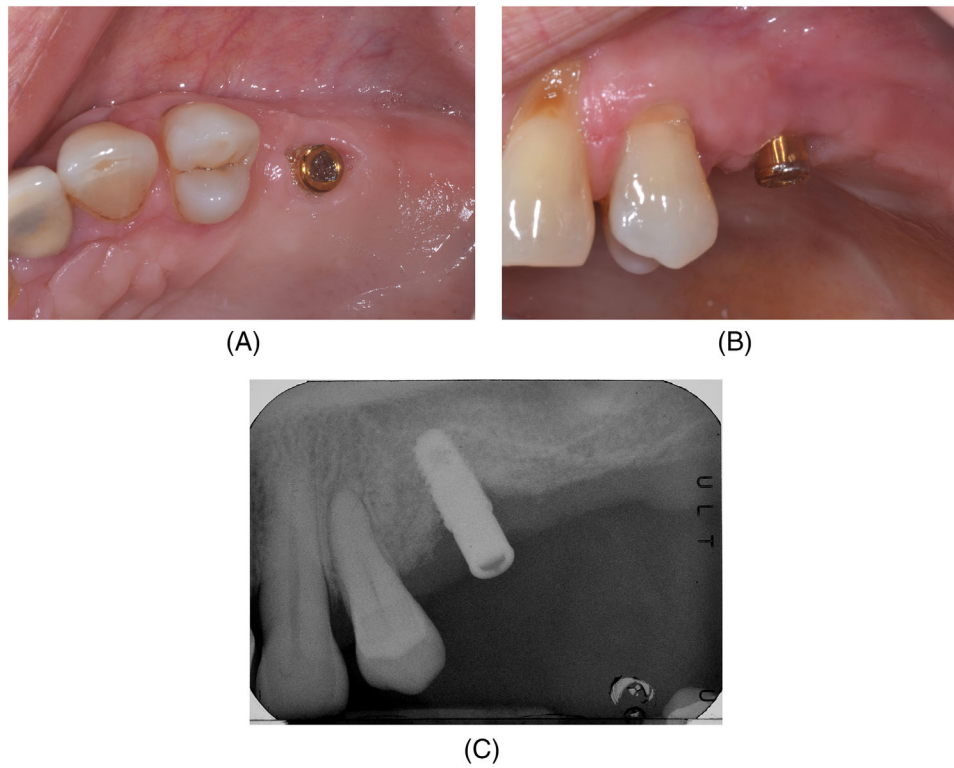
Clinical (A, B) and radiographic (C) 1-year follow-up after prosthetic abutment was re-inserted, without clinical signs of inflammation or radiographic bone loss.
